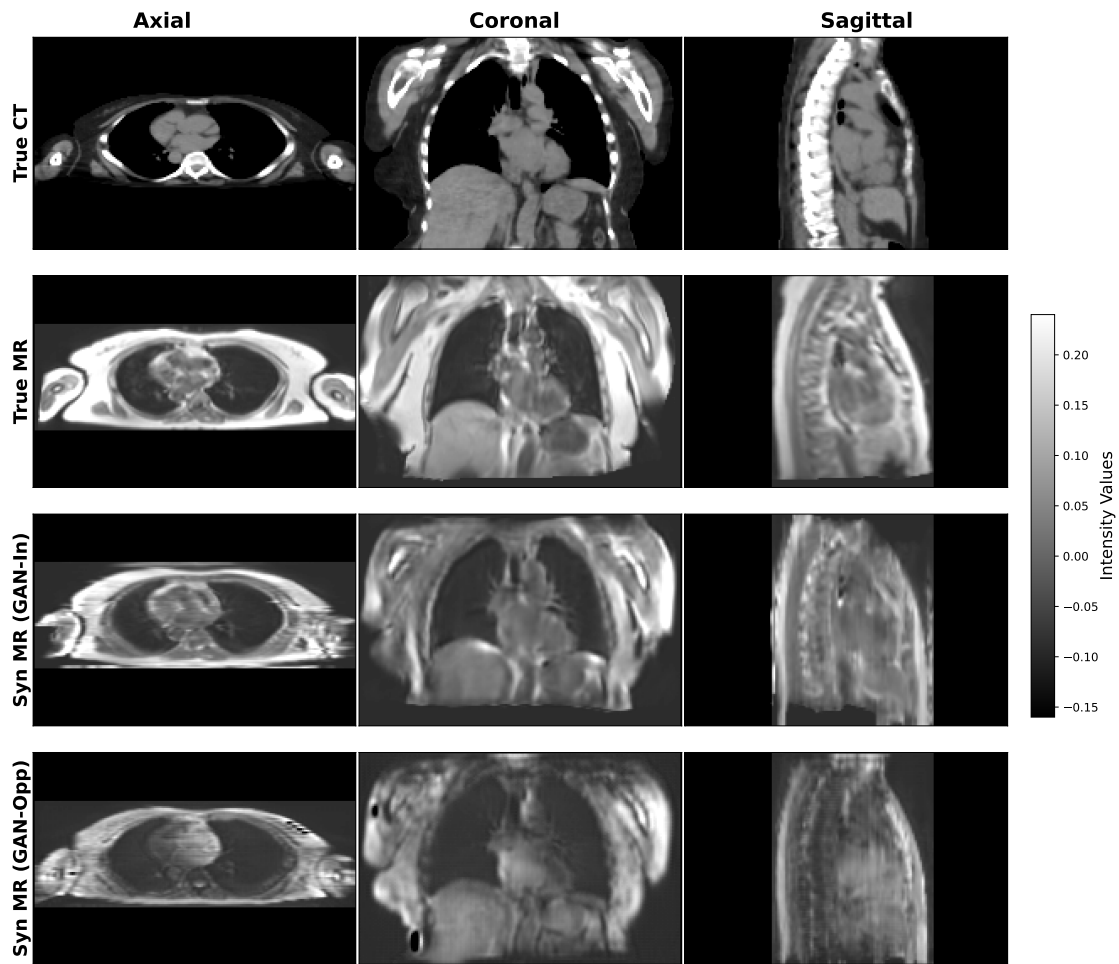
Comparison of true and synthetic MR images. The figure shows axial, coronal, and sagittal views of (top to bottom): reference CT scan, true MR scan, synthetic MR (In) generated by GAN-In model, and synthetic MR (Out) generated by GAN-Out model. The synthetic MR images demonstrate the capability of the GAN models to transform CT data into MR-like representations while preserving anatomical information.
